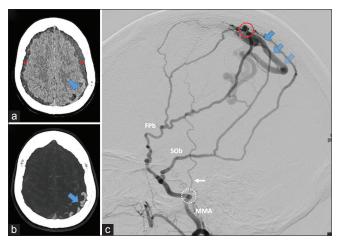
Preoperative imaging. (a and b) Head computed tomography scan. A (noncontrast acquisition): bilateral cSDH (red asterixis) and left extra-axial structures suspected to be abnormal vessels (blue arrow). (b) (Maximum Intensity Projection [MIP] reconstruction from CT angiography): the structures are identified as dilated cortical veins (blue arrow). C (left middle meningeal artery [MMA] digital subtracted angiography [DSA], lateral view): dAVF depending on frontoparietal and squamo-occipital MMA branches (respectively, FPb and SOb). The shunt (red circle) is directly on a tortuous left parietal cortical vein (blue arrows) with secondary drainage within the superior longitudinal sinus (Cognard Type III dAVF). The foramen spinosum (white dotted circle) and the temporal artery (white arrow) are depicted as anatomical landmarks.
